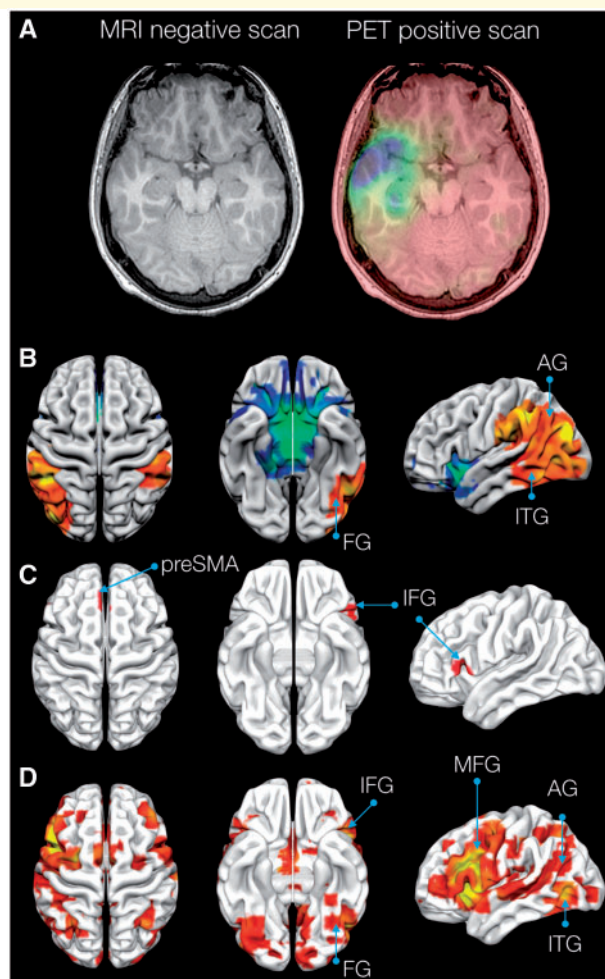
The 'hidden lesion'. (A) MRI-negative and PET-positive scans of the same patient (from Jha *et al.*). (B) Metabolic lesion-symptom map for phonemic verbal fluency as identified by Jha *et al.* (C) Example of a structural lesion-symptom map for phonemic verbal fluency as obtained from Kinkingnéhun *et al.* (2007). (D) Functional activation maps from healthy controls performing a verbal fluency task in an MRI scanner. Maps derived from Neurosynth (www.neurosynth.org, Yarkoni *et al.*, 2011). AG = angular gyrus; FG = fusiform gyrus; IFG = inferior frontal gyrus; ITG = inferior temporal gyrus; MFG = middle frontal gyrus; preSMA = presupplementary motor area.
